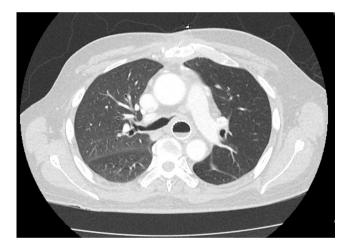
CT chest shows obstruction of the left mainstem bronchus immediately after deployment of an esophageal stent
